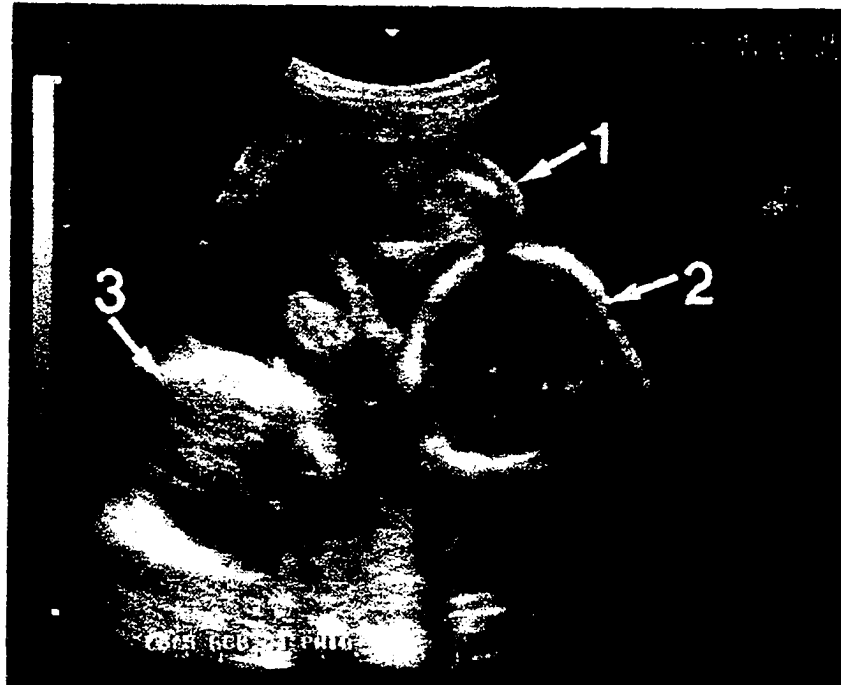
A representative B-scan image, where the brightness values of each pixel represent the strength of the return echo. The image is of triplets scanned using fetal ultrasound [77].
